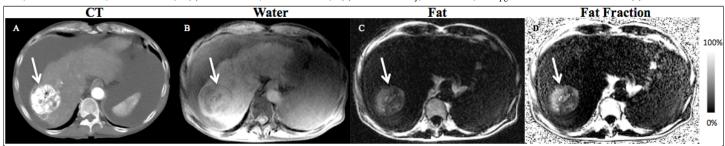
Images from a 71-year-old male with cirrhosis and a known HCC in the right lobe of the liver treated with ethiodol based TACE. An arrow shows the tumor location in each image. A) CT demonstrates a hyperdense region corresponding to the ethiodol distribution. Separated b) water, c) fat and d) calculated fat-fraction images are also shown.
